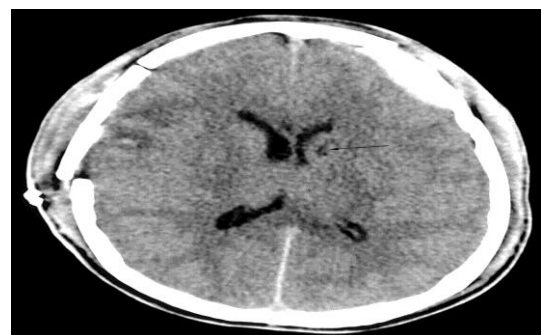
Demonstrate CT image of severe head injury (black arrow)
